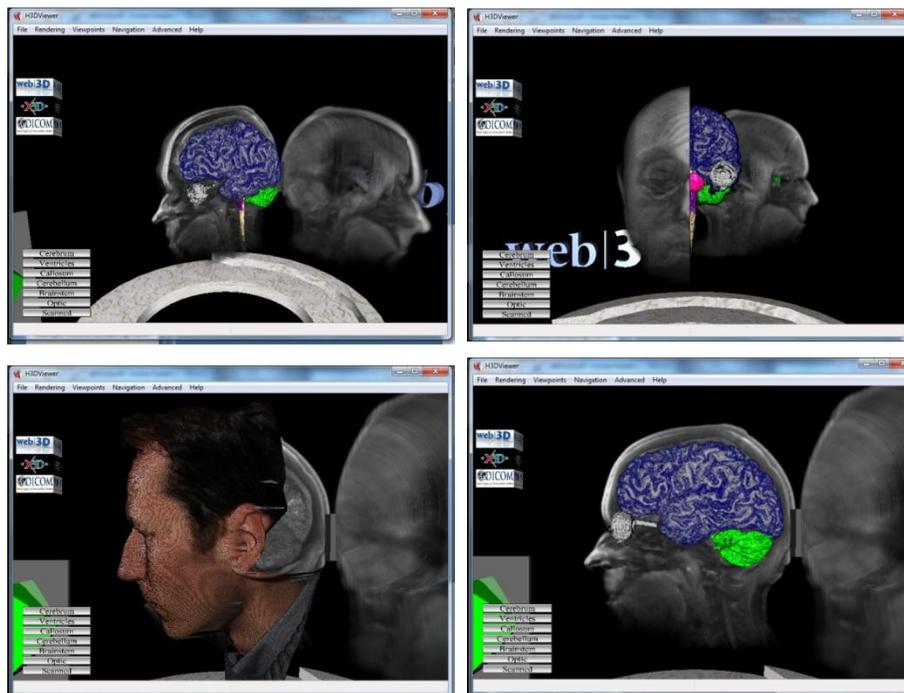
X3D 3.3 Segmentation application of a brain MRI and a patient face scan
